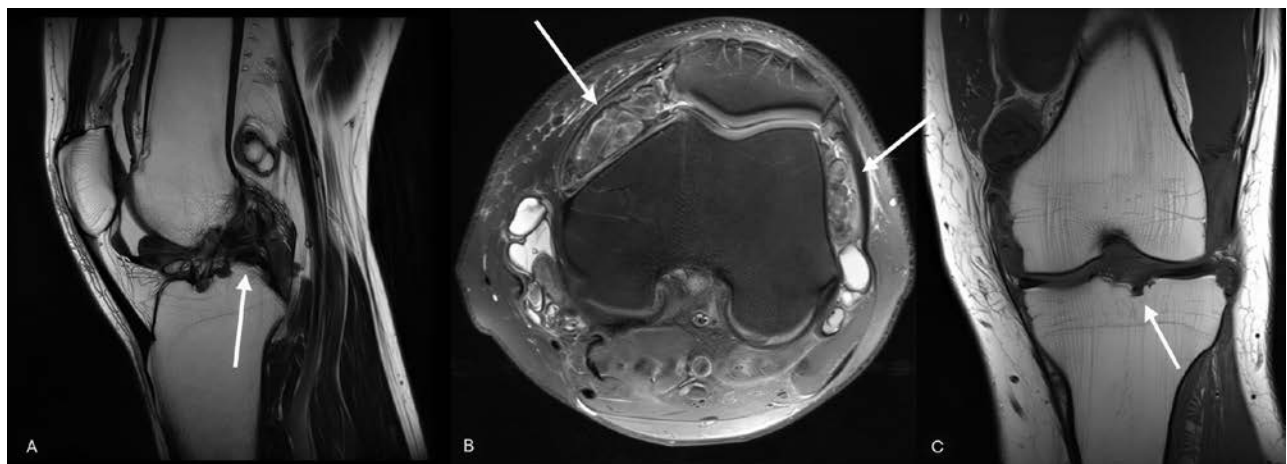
MRI of the knee demonstrates diffuse intra-articular TSGCT with extensive synovial proliferation (arrows, A-B). The lesion shows diffuse, ill-defined synovial thickening on PD-fs (A) and solid components of low-to-intermediate signal intensity on PD (B) non-contrast-weighted sequences, associated with marked synovial thickening (arrows, A-B) and adjacent bone erosions on T1-WI (arrow, C).
